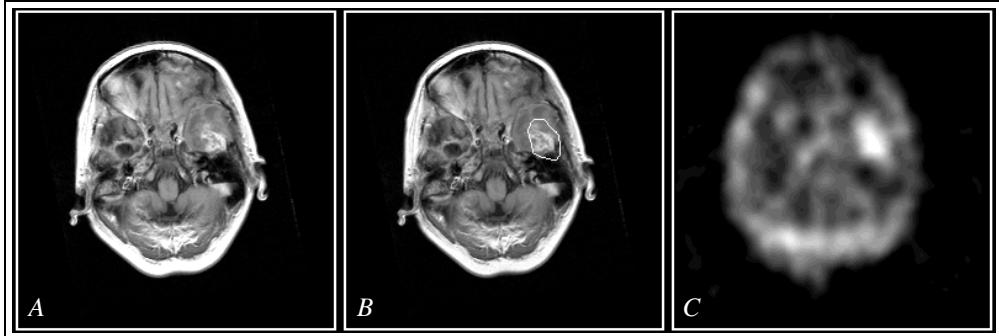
Registration of Thallium–SPECT and MRI using Mutual Information. The image data are taken from a patient with a left temporal lobe abnormality which is indicated by the contour from the abnormal Thallium–SPECT region superimposed onto the MR image. Frame (A) MR image, (B) integrated image, (C) Thallium–SPECT image.
